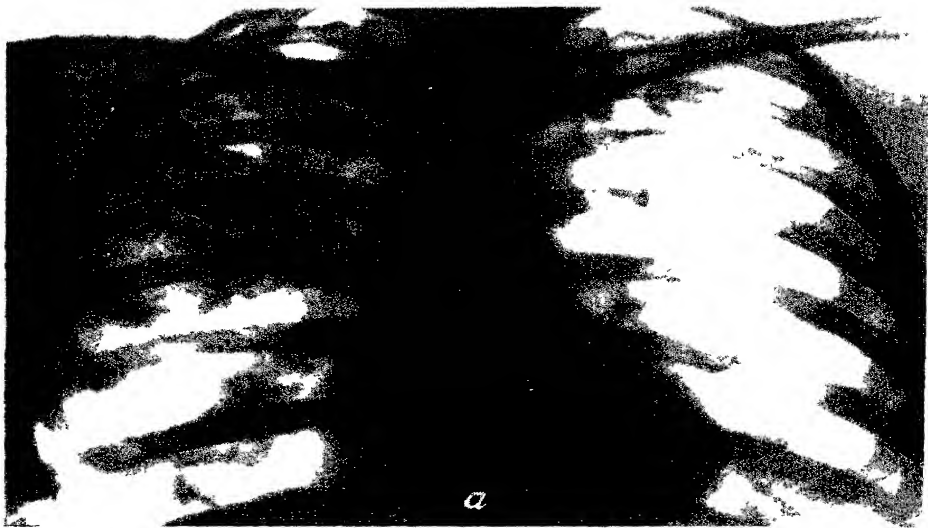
X-rays of patient K V.
